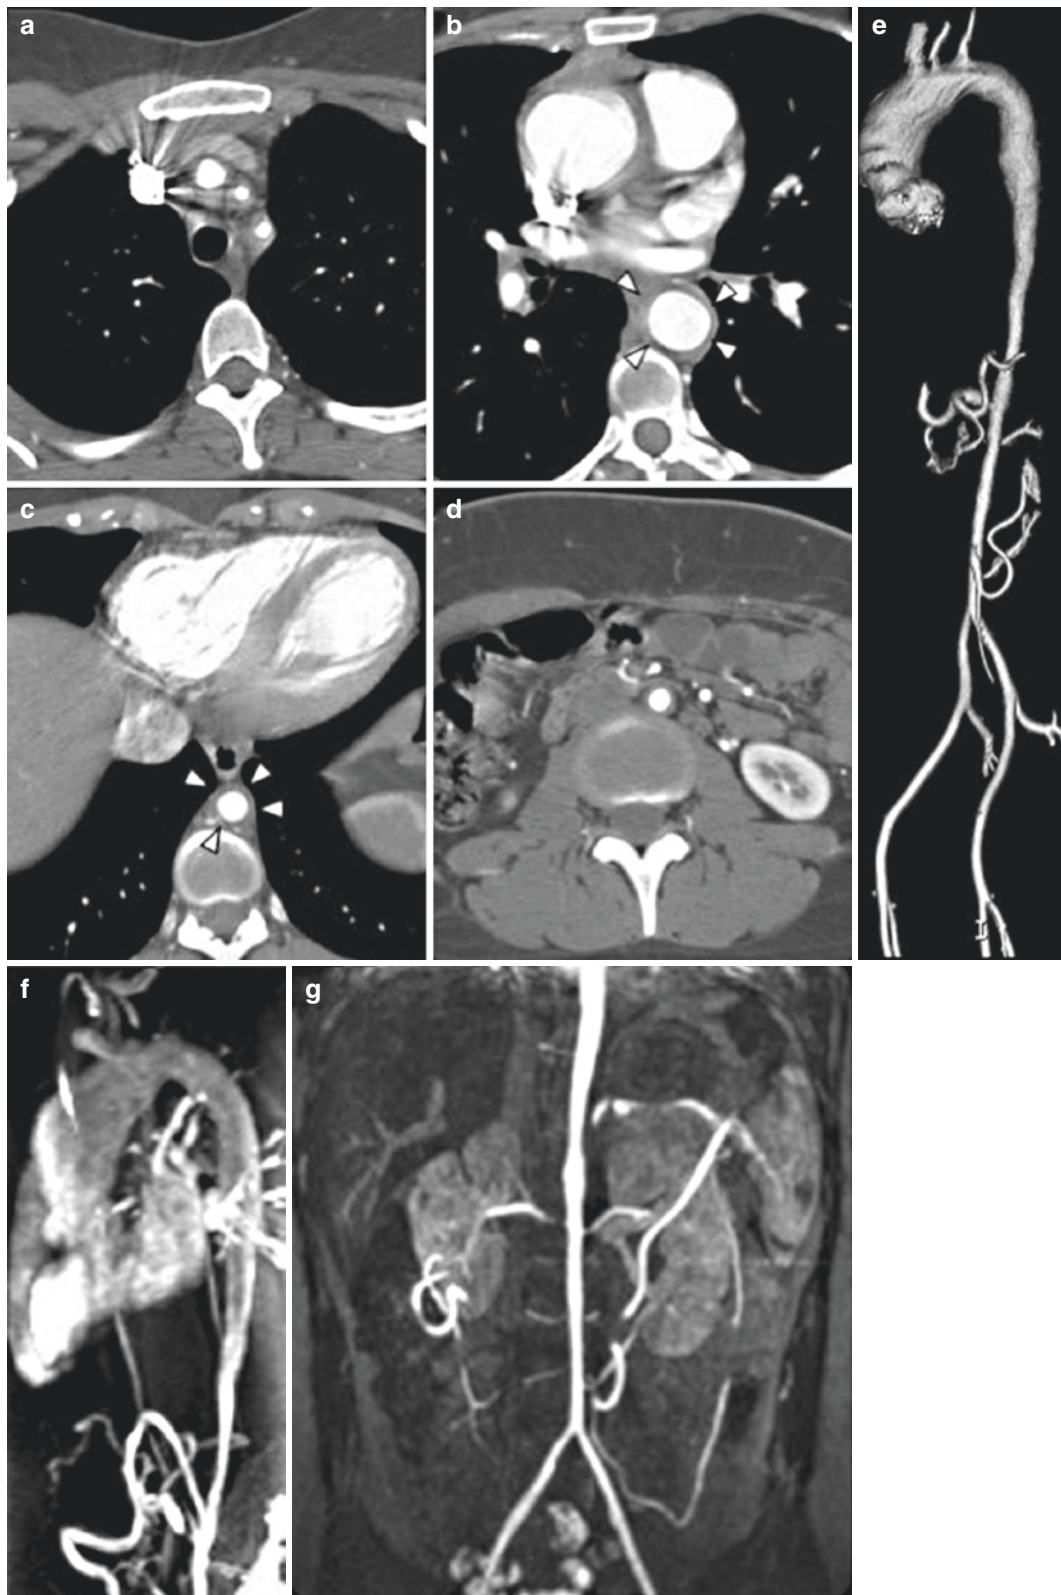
Takayasu arteritis with involvement of the thoracoabdominal aorta and great vessels as shown on contrast-enhanced CT and MR studies, noting the narrowing of the arterial lumen and circumferential soft tissue thickening of the walls of the vessels. (a) Narrowing of the left common carotid and left subclavian arteries. (b) Mid-descending aorta. (c)
